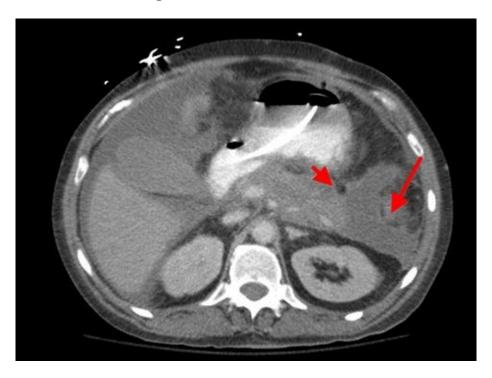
CT scan of the abdomen showing fluid collections (arrows).
